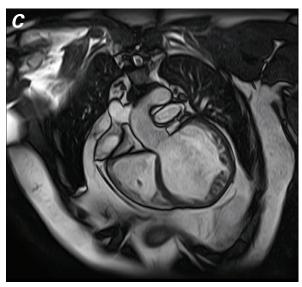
At presentation, cardiac magnetic resonance images show the globally hypokinetic left ventricle and noncompacted myocardium in A) short-axis, white-blood view, B) 4-chamber, white-blood view at the lateral wall and apex, and C) coronal oblique view parallel to the left ventricular outflow tract.
